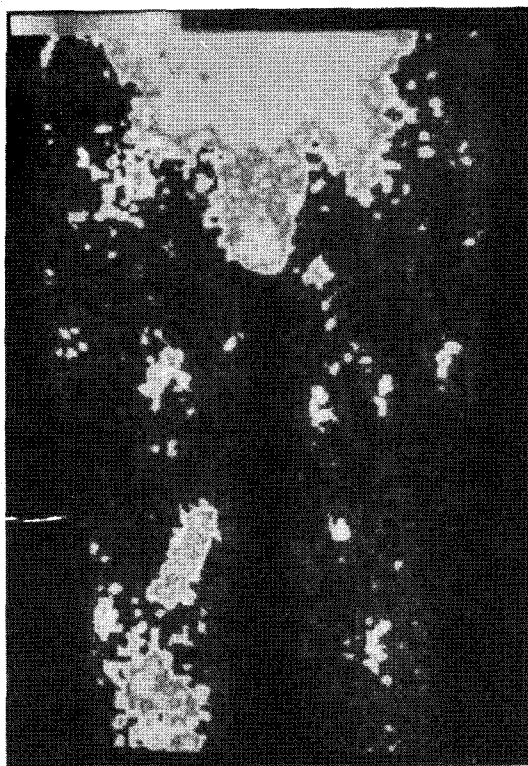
Localization of In-111 labeled monoclonal antibody in both lower extremities (case 2). Multiple deposits of In-111 was seen throughout the subcutaneous metastases from malignant melanoma with the size of 1 to 2 cm in diameter. The scintigram was taken 3 days after the injection of 20 mg and 2 mCi of In-111 labeled anti-p97 monoclonal antibody(96.5).
